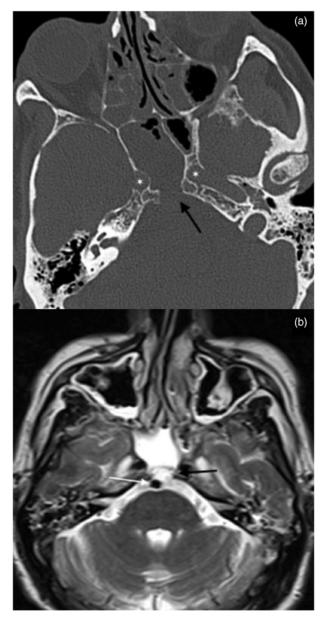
Case 2: (a) pre-operative axial computed tomography scan images showing bone erosion (black arrow) of the posterior wall of the sphenoid sinus and clivus between the paraclival carotid arteries (white asterisks); (b and c) pre-operative axial and sagittal T2-weighted magnetic resonance imaging demonstrates a lesion (black arrow) in the posterior wall of the sphenoid sinus which derives from the prepontine cistern, and the lesion appears to be in contact with the basilar artery (white arrow); and (d) intra-operative neuronavigation image demonstrating the navigated suction tip pointing out the lesion (white arrow) between the paraclival carotid arteries and inferior to the sella turcica.
